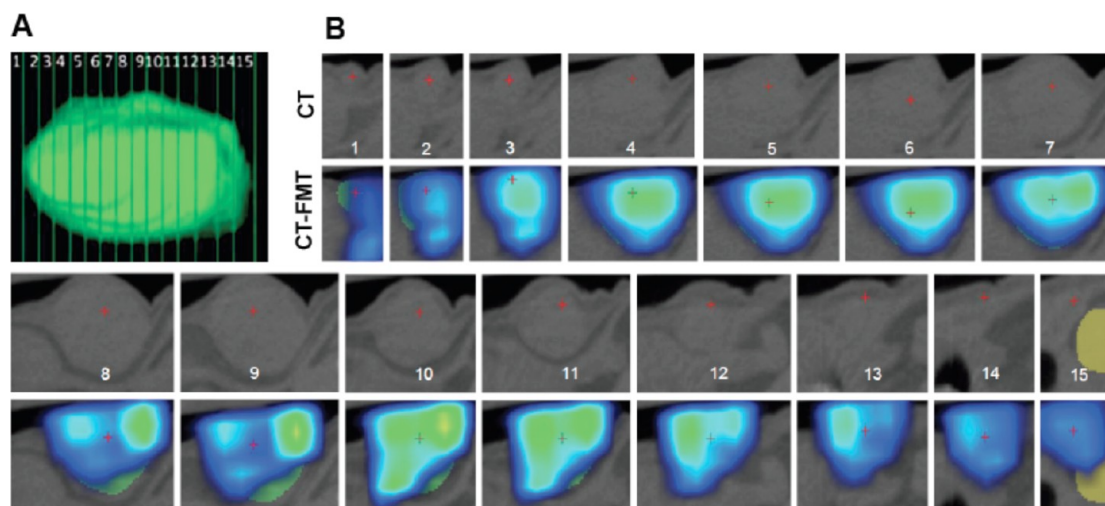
Monitoring the intratumoral distribution of pHPMA-Dy750 using 3D CT-FMT. (A,B) Accumulation of pHPMA-Dy750 in 15 consecutive 0.5 mm wide cross-sectional CT slices (A) was evaluated using hybrid 3D CT-FMT, exemplifying inhomogeneous intratumoral probe distribution, with lower levels in the core vs the periphery (B).
